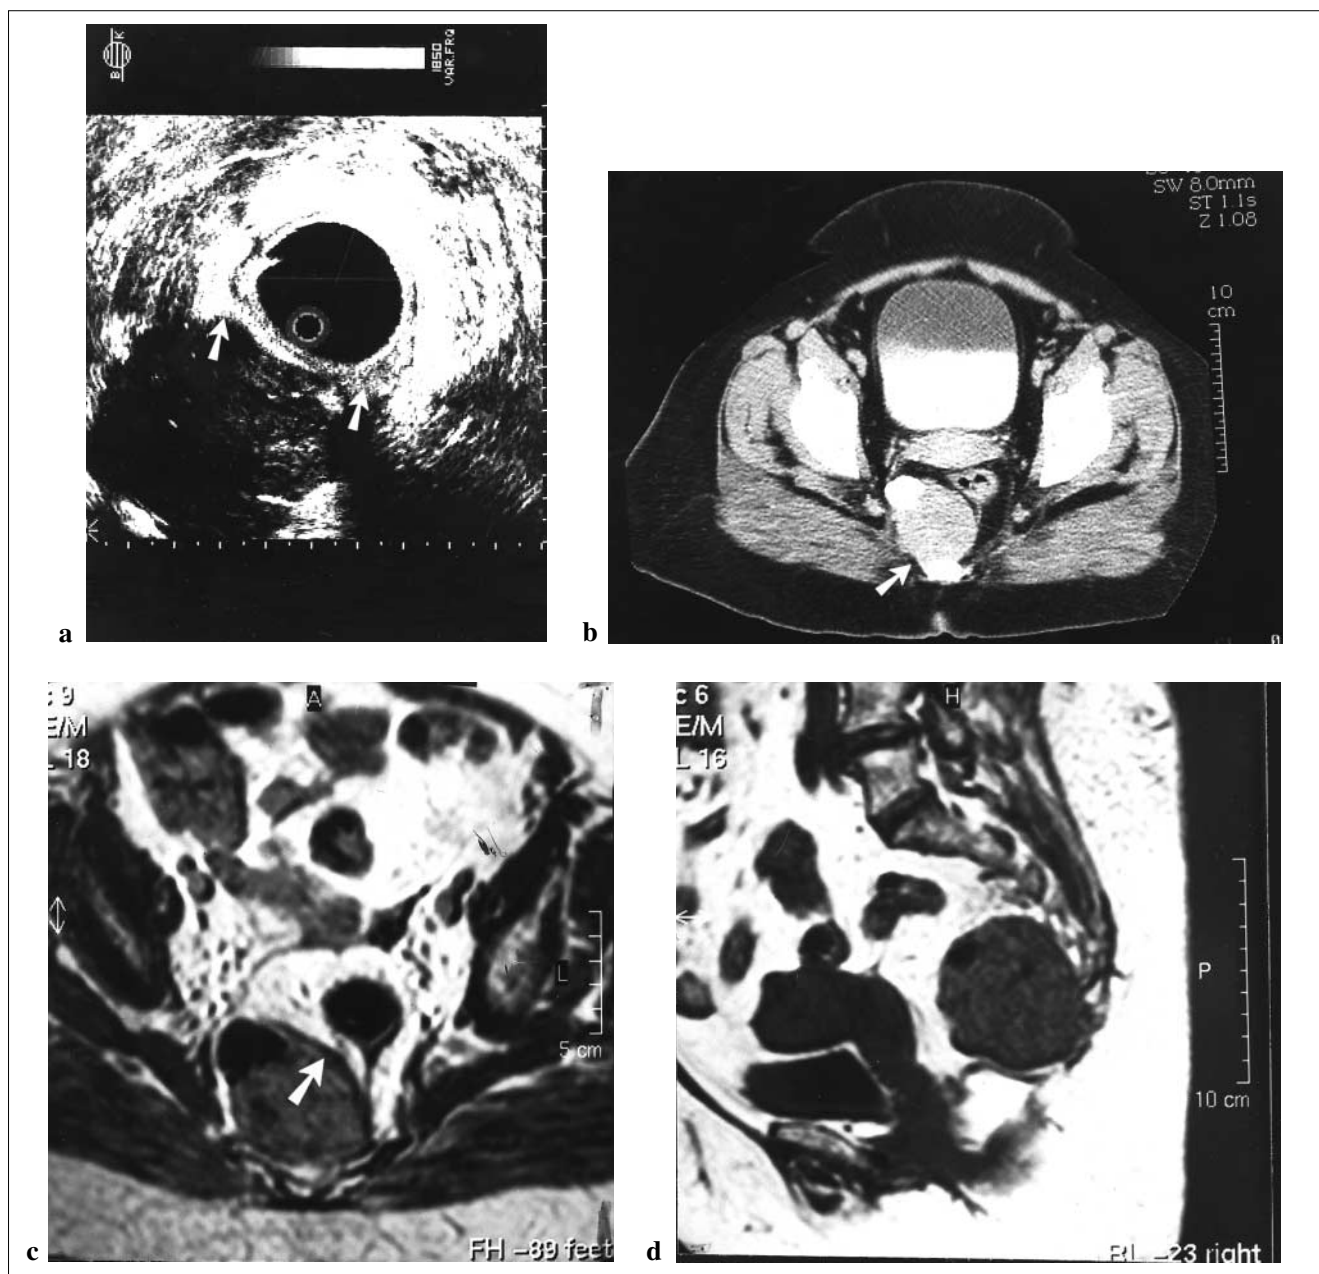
a Endorectal ultrasound (ERUS) of the presacral mass, showing infiltration of the echogenic rectal muscularis (*arrows*). b CT scan showing axial views of the mass (*arrow*). Information with this modality is limited in discerning the relationship between the tumor and the rectum or the exact tumor level. c Axial MRI showing a clear edge between the heterogeneous mass and the rectal wall (*arrow*). d Sagittal MRI showing the level of the tumor extending to the tip of the coccyx with a clear boundary between the posterior aspect of the mass and the presacral fascia
